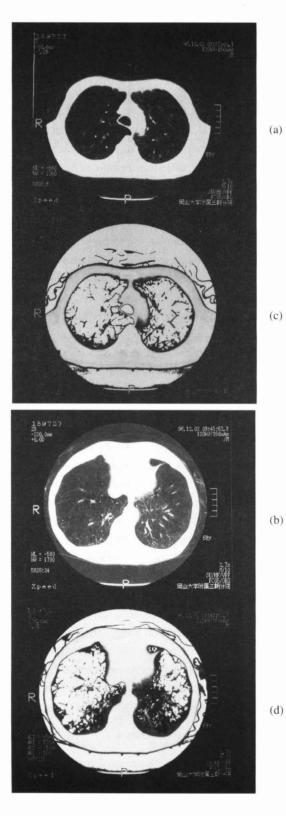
HRCT scan showing emphysematous change such as many low attenuation areas (LAAs) in the lung fields (a,b). HRCT findings were also analyzed quantitatively, defining lung areas with CT numbers less than -950 Hounsfield Units (HU) as LAAs. The percentages of LAAs on HRCT were 72.6% at the top of the aortic arch (c), and 49.3% at a level of 2 cm above the diaphragm (d).
